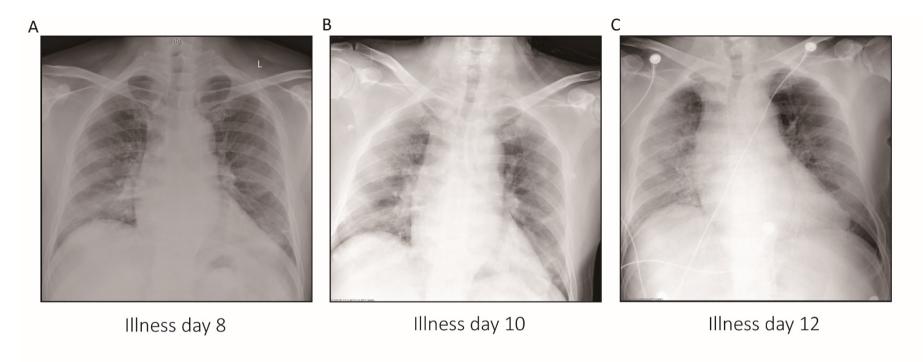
Chest radiographs on day 8, day 10 and day 12 since the onset of illness. (A) The brightness of both lungs was decreased and multiply patchy shadows were observed. Heart shadow presents in the normal range roughly. The diaphragmatic surface was light and smooth, rib phrenic angle was sharp (illness day 8). (B) Diffuse ground-glass opacity was found in both lungs (illness day 10). (C) Chest radiograph showed progressive infiltrate, diffuse gridding shadow appeared in both lungs. Small area emphysemas were observed in upper and lower lobes of left lung (illness day 12).
